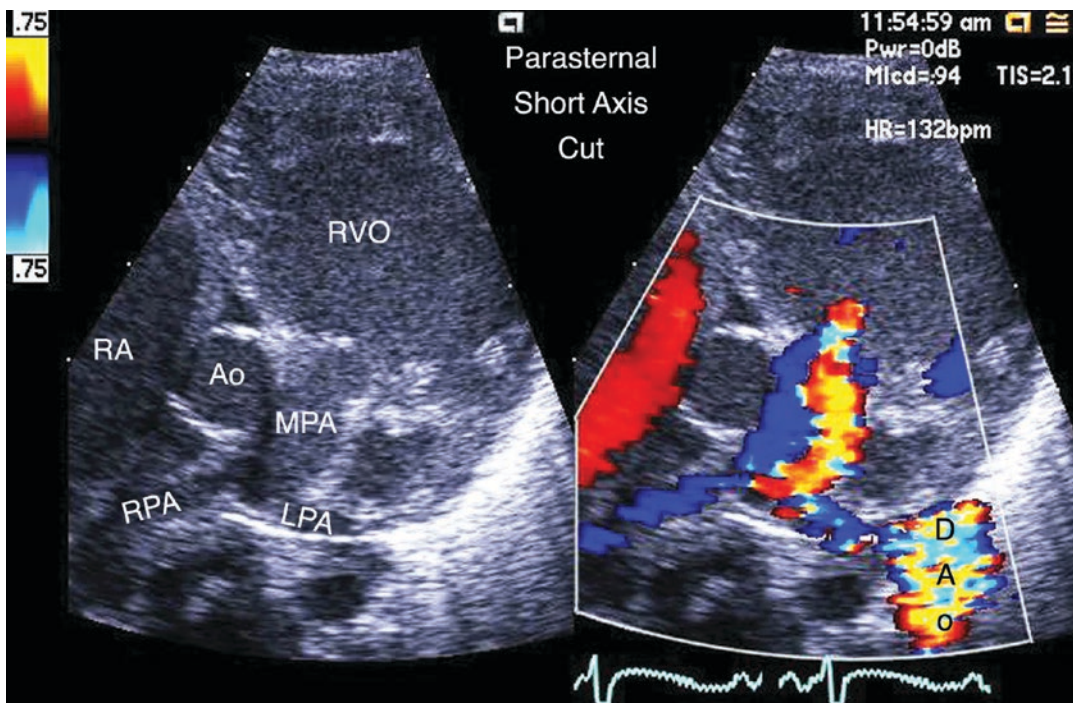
This figure, taken in the parasternal short axis cut at the level of the great arteries, is a gray scale and Doppler color flow simultaneous recording in late diastole in an infant. The main (MPA) and left and right branch pulmonary arteries (LAP, RPA) are small and there is some regurgitation into the right ventricular outflow indicating pulmonary insufficiency. There is also a ductus left-to-right shunt noted by the *red* and *yellow* stream
